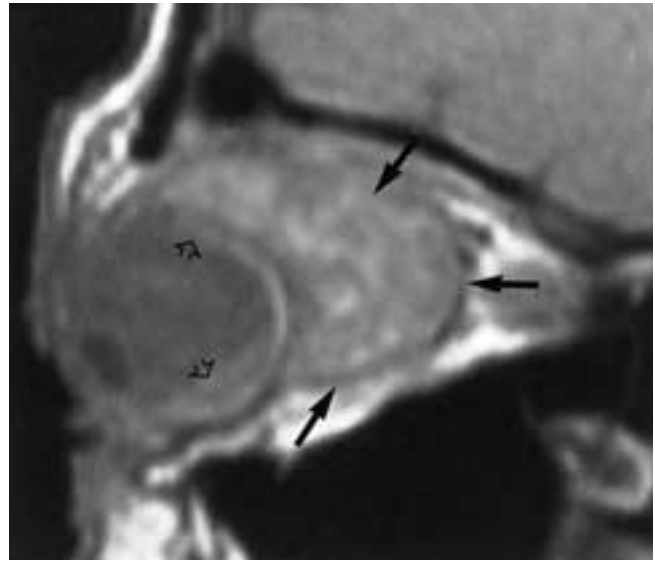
Uveal melanoma with extension into Tenon's capsule. Sagittal PW MR image shows a large, well-capsulated retrobulbar mass (*arrows*) in this patient with uveal melanoma (not seen in this section). Note the subretinal fluid (*open arrows*). Surgery confirmed the intraocular tumor and massive extension into Tenon's capsule.
